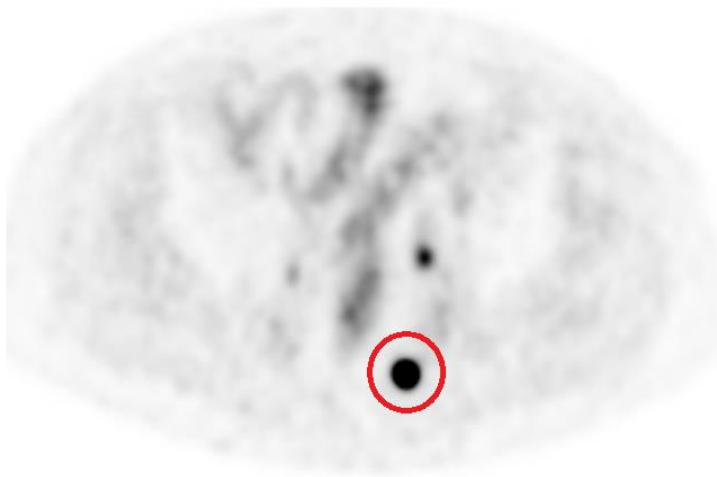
Suspicion for left mesorectal lymph node involvement on pre-operative  $^{68}\text{Ga}$ -PSMA PET/CT in patient #12 (SUVmax 49). The probe successfully identified the node (in-vivo node count of 183) and final pathology showed a 8mm malignant lymph node.
